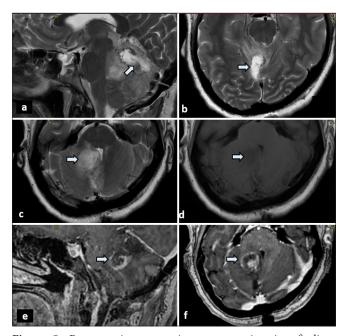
Postoperative magnetic resonance imaging findings after the first surgery. (a). Sagittal T2-weighted image reveals a resection cavity (arrow). (b). Axial T2-weighted image shows the resection cavity (arrow). (c). Axial T2-weighted image displays a rounded hyperintense lesion with a hypointense rim in the right cerebellar hemisphere paravermian location (arrow).(d). Axial T1weighted image shows the lesion appearing hypointense (arrow). (e). Sagittal T1 postcontrast image demonstrates nodular peripheral enhancement of the lesion (arrow). (f). Axial T1 postcontrast image also shows nodular peripheral enhancement of the same lesion (arrow), suggestive of residual disease.
